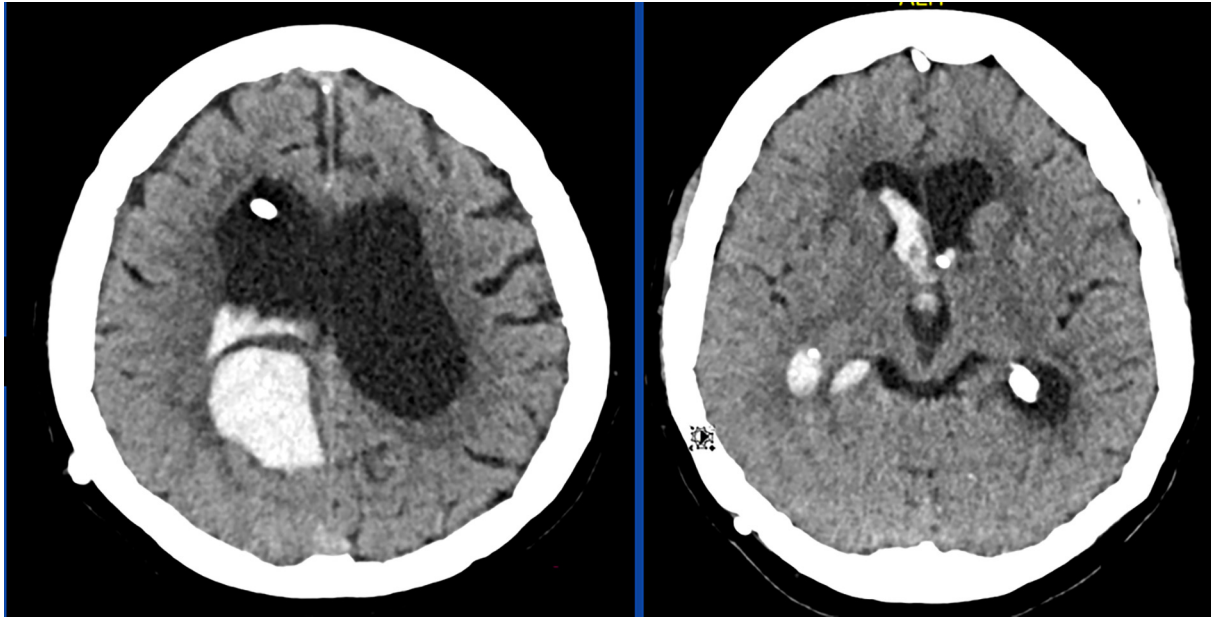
CT-scan of the brain showing an intracerebral bleeding in the right parietal region with ventricular rupture and blood within the 1st and 3rd ventricle. To prevent the development of hydrocephalus, a ventricular drainage had been placed from the right frontal side.
